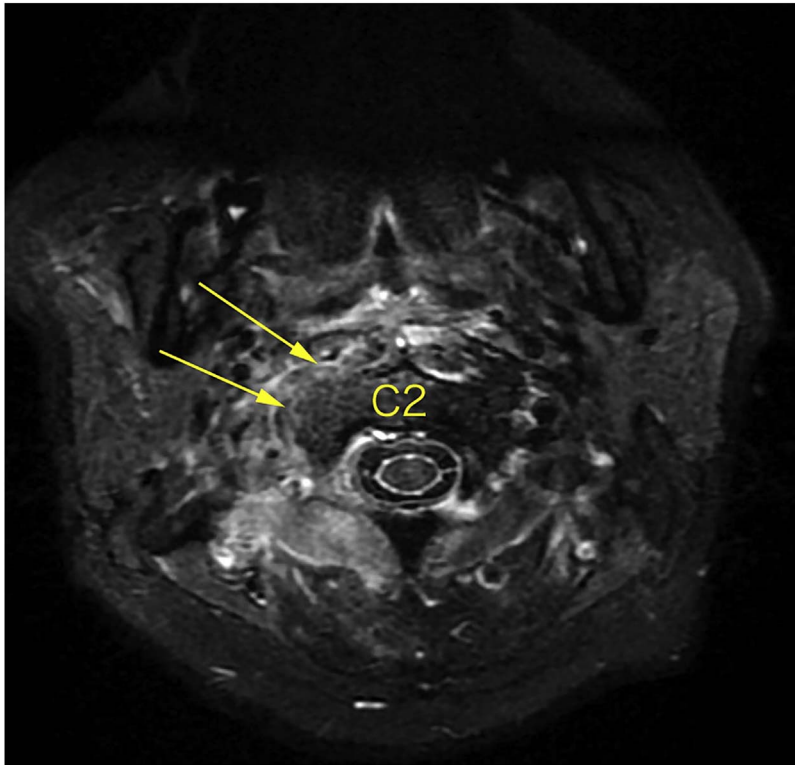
The right side of C1/C2 vertebral bodies demonstrating abnormal marrow signal and enhancement consistent with osteomyelitis on cervical spine MRI (short tau inversion recovery).
